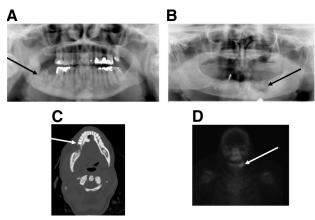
Radiographic characteristics of ONJ. (A): Panoramic radiograph of a nonhealing extraction socket showing progressive bony destruction in the right mandible (arrow). (B): Panoramic radiograph of spontaneous ONJ showing bony sequestrum in the left mandible (arrow). (C): Axial view of a computed tomography scan demonstrating a lytic lesion in the right body of the mandible (arrow). (D): Anterior view of bone scan showing increased uptake in the left mandible (arrow).
